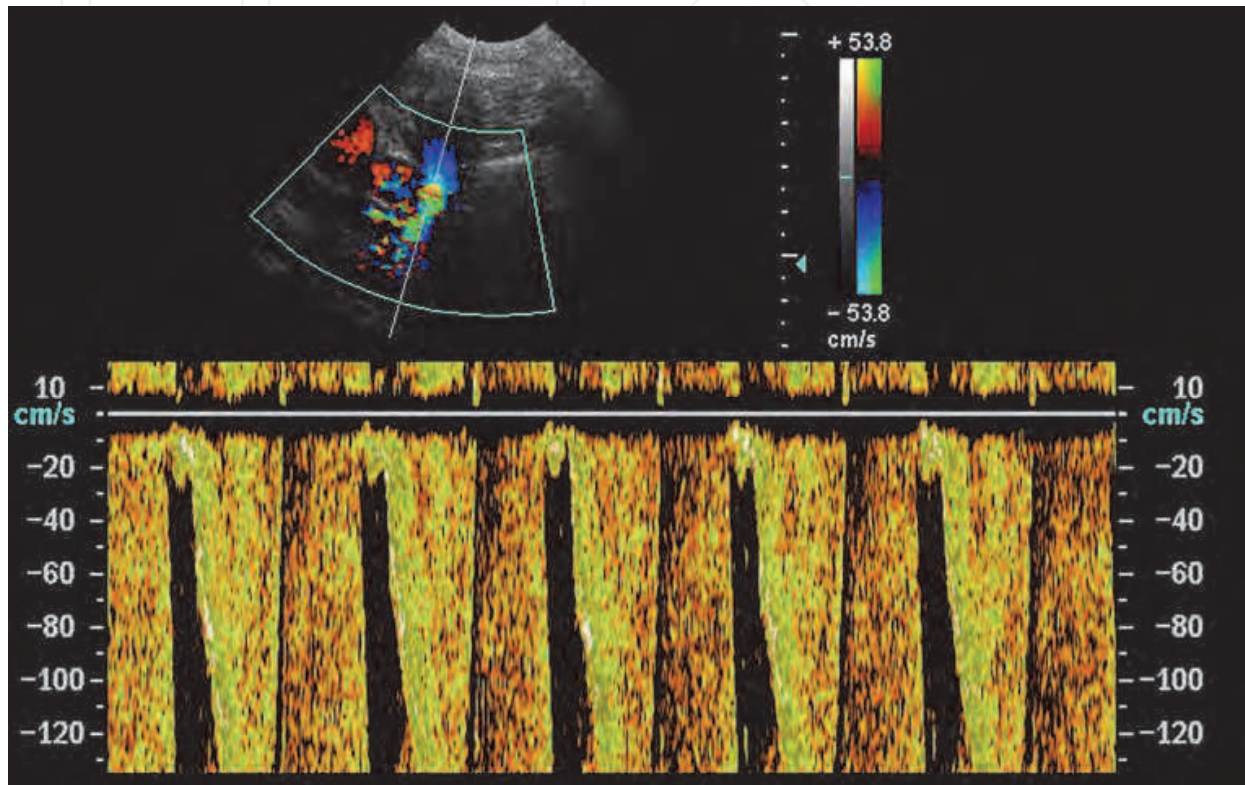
Non-optimised spectral trace obtained by means of pulsed Doppler. The PRF (pulsed repetition frequency) is too low.
